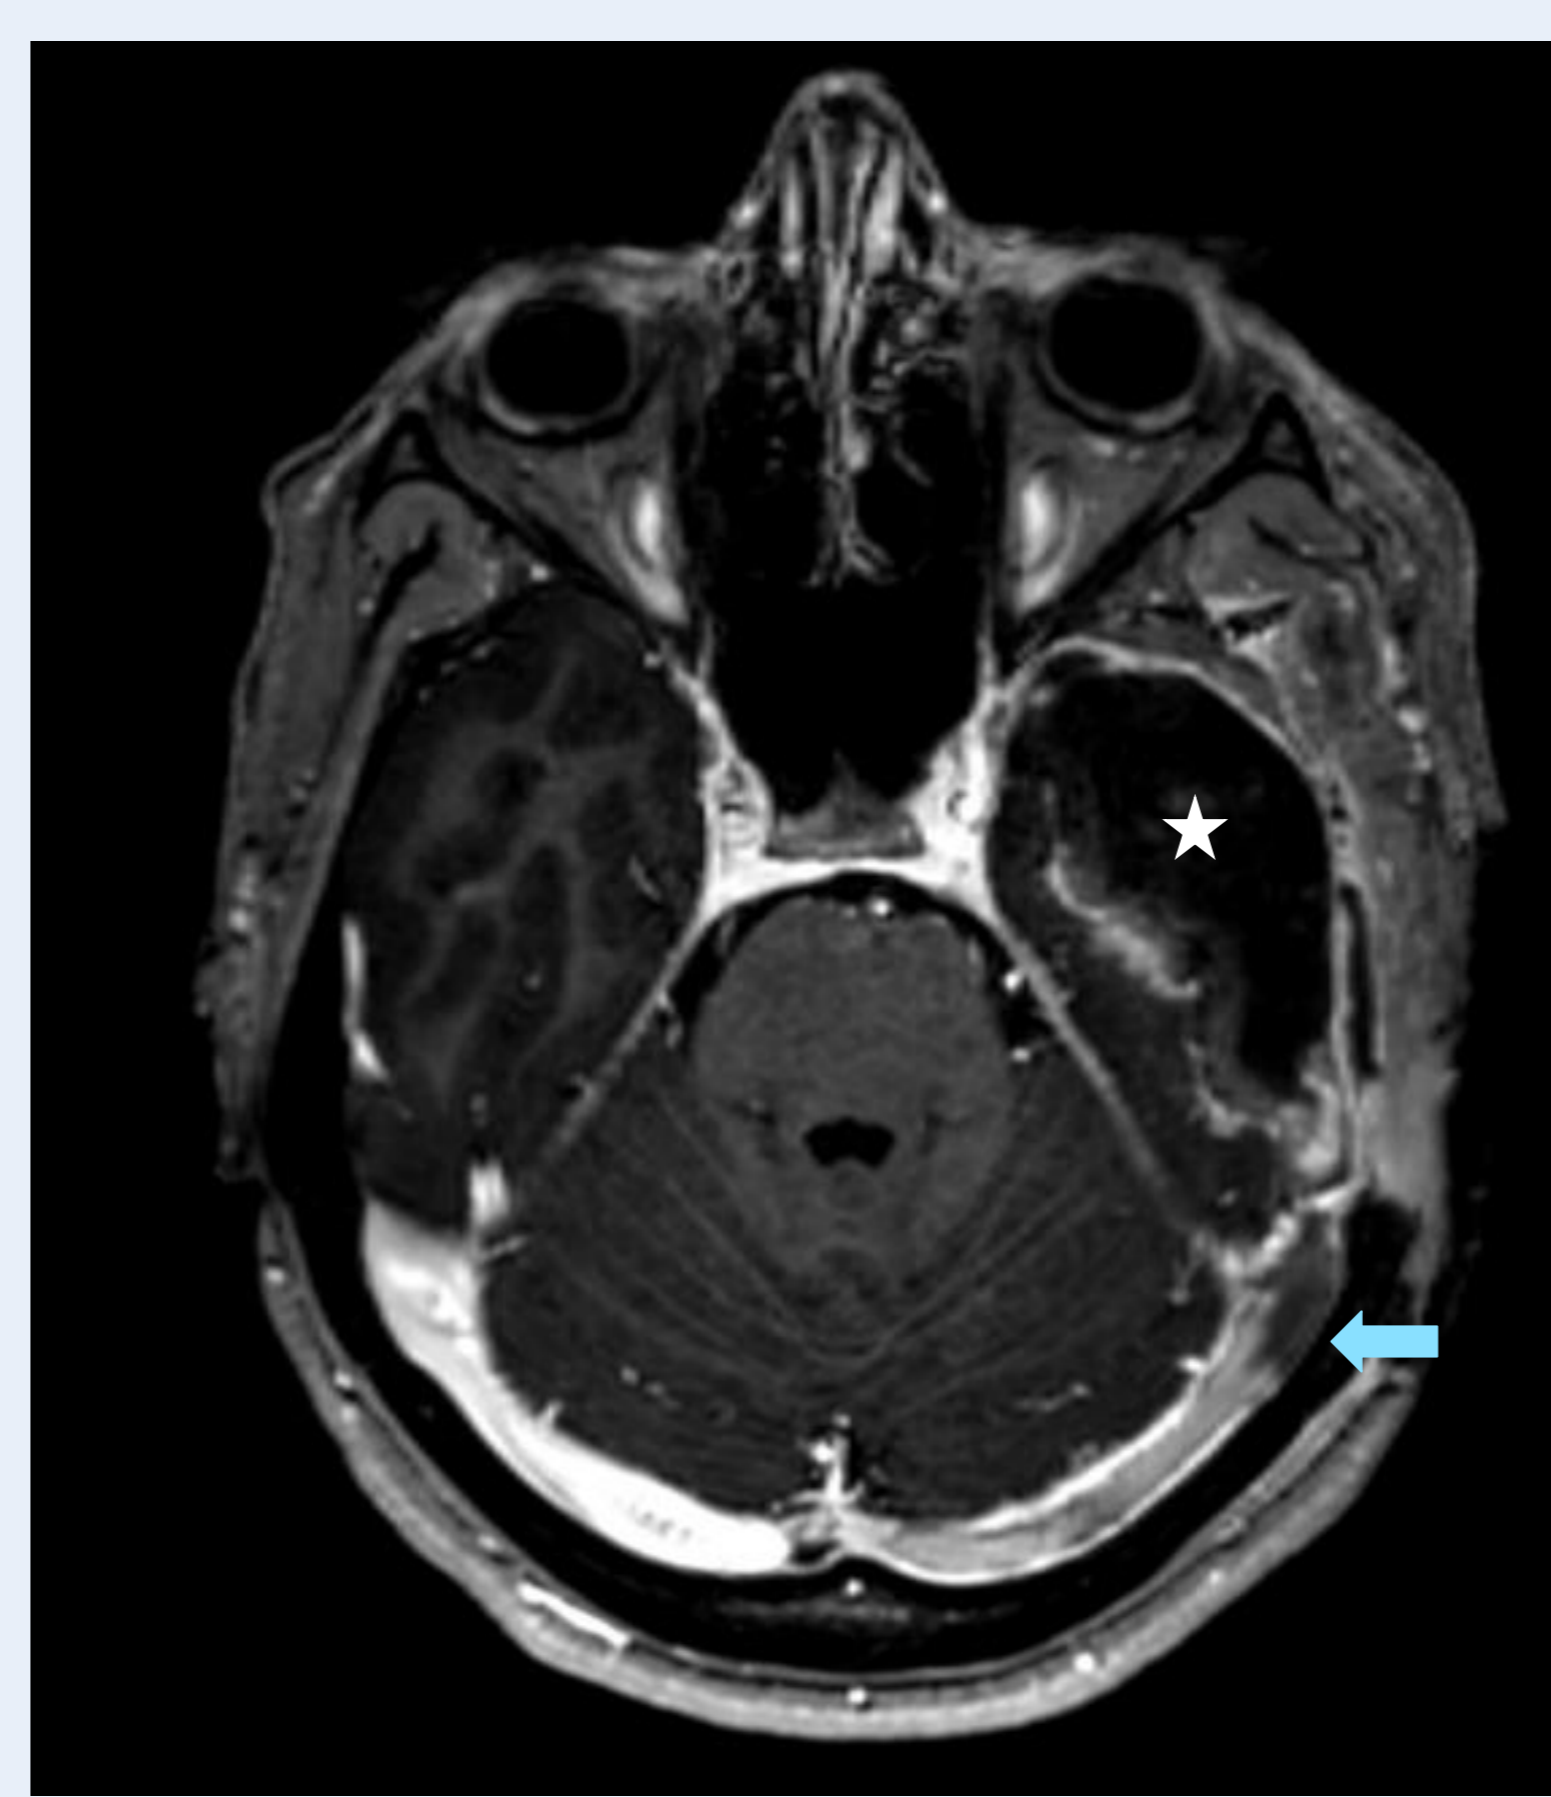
postoperative MRI scan demonstrating the anterior temporal lobectomy (white asterisk) and the presence of a thrombus in the left sinus transversus (white arrow) and sinus sigmoideus (red arrow).
